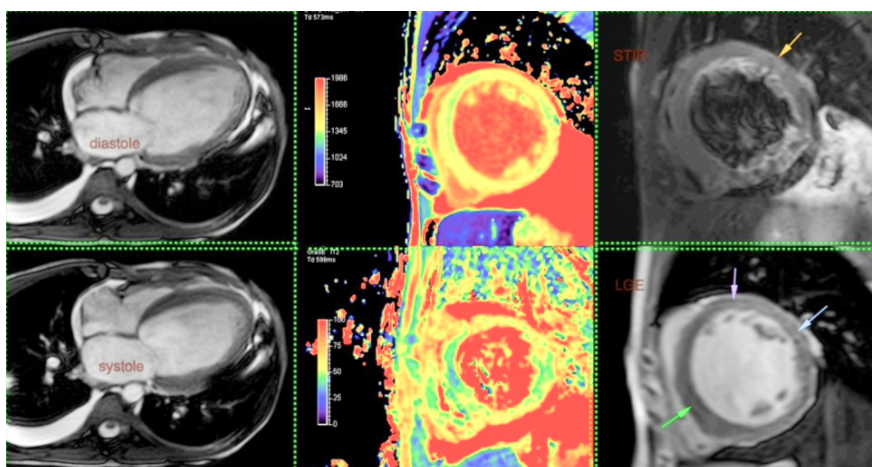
Contrast-enhanced CMR performed on the third day of hospitalization showed increased mid-myocardial enhancement in T1-weighted images.
